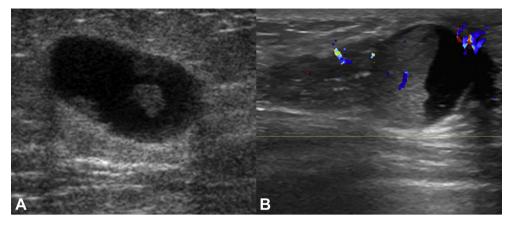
Miscellaneous type: lesions with sonographic features not fitting the other three patterns. (A) A low-grade ductal carcinoma *in situ* (DCIS) lesion presented as an ovoid cystic lesion with small mural polypoid nodules and posterior acoustic enhancement and (B) a high-grade DCIS lesion contained cystic component and conspicuous solid tumor, which demonstrated internal hypervascularity on color Doppler ultrasound.
